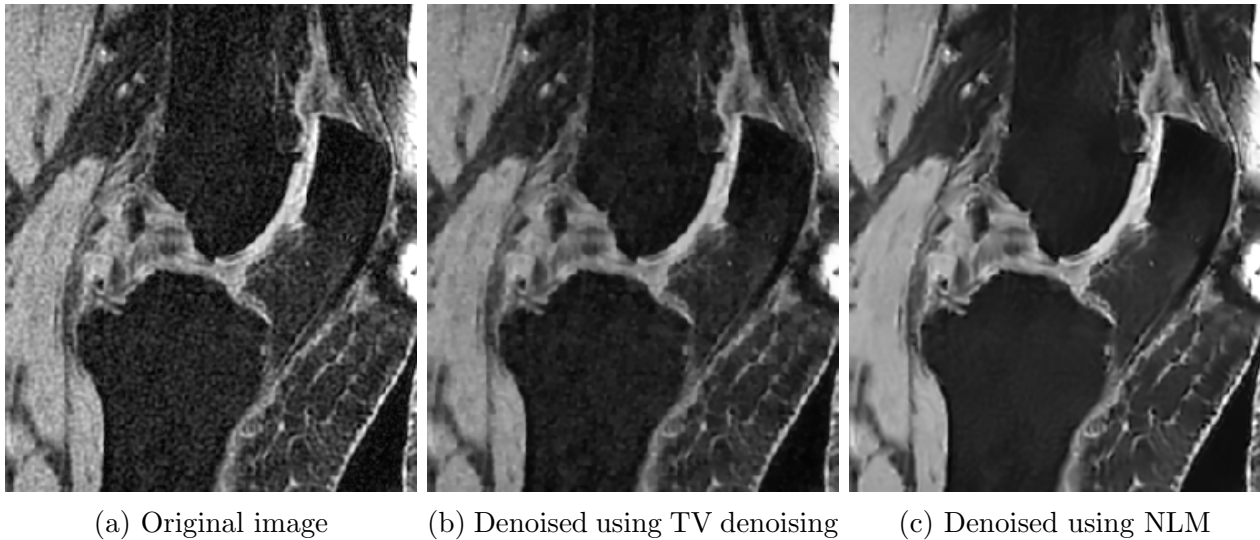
An example of noise present in knee MRI, shown in (a), with the result of applying TV denoising shown in (b) and nonlocal means in (c).
